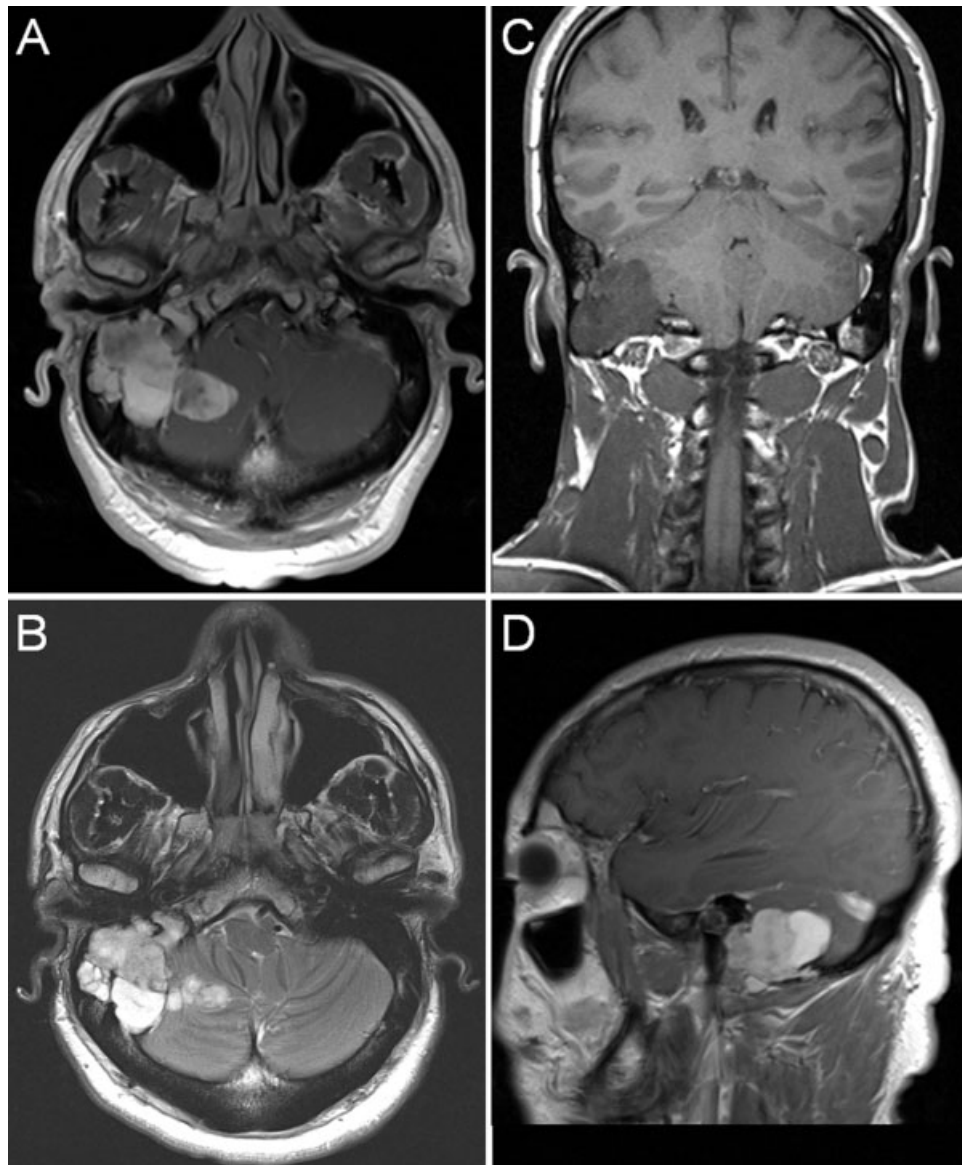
Preoperative magnetic resonance imaging. (A) Axial T1, (B) axial T2, (C) coronal T1, and (D) sagittal T1-weighted images reveal a variably enhancing mass in the right mastoid air cells extending medially along the floor of the posterior fossa, extending inferiorly into the parotid bed and medially into the cerebellum.
